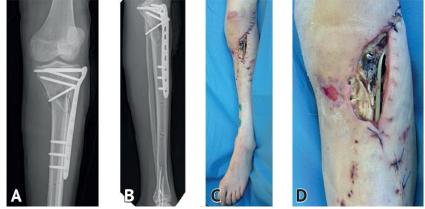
X-rays of the patient's left lower leg after osteosynthesis of the fracture of the proximal tibial metaepiphysis (A, B). View of the patient's left lower leg 10 days after osteosynthesis (C, D)
